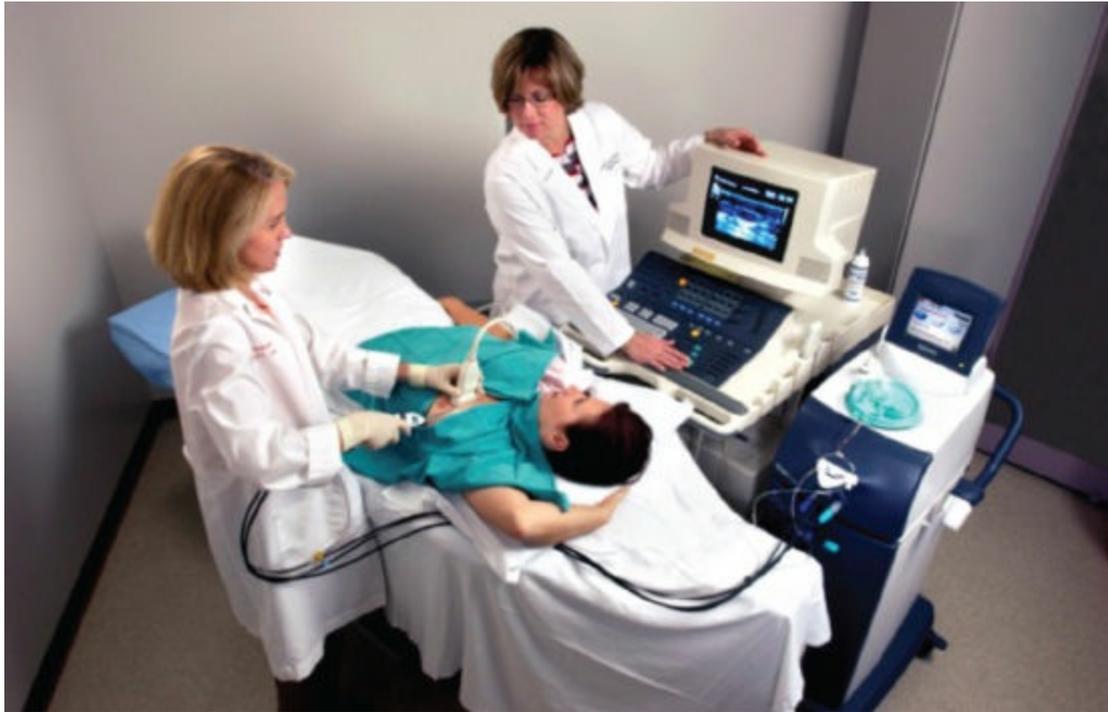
Ultrasound-guided breast biopsy. (Courtesy of Mammotome.)
